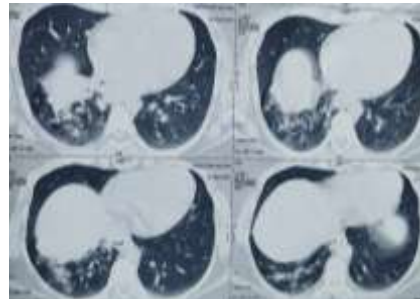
Repeat PET-CT (26 August 2024)
